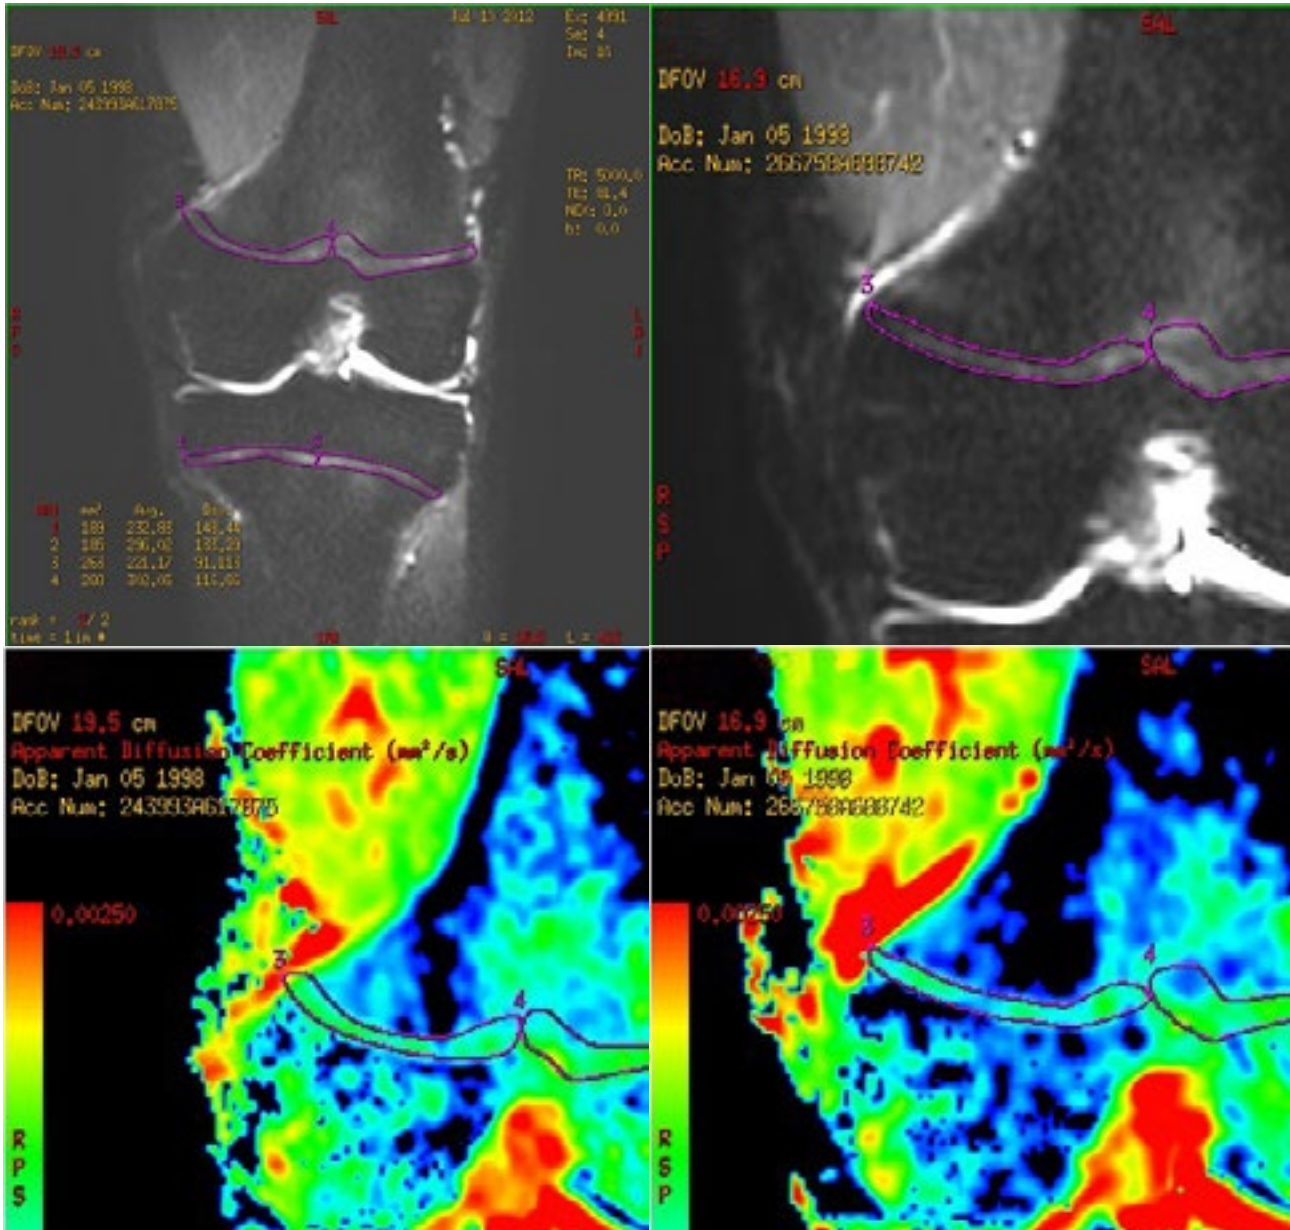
A sample of DWI analysis of growth plate in an adolescent soccer player before (A, A1) and two months after (B, B1) sport activity. There were no significant differences in growth plate surface area measured in MR images (A, B). Calculated ADC values after 2 months were decreased and may reflect an increased cellularity of the growth plate (A1, B1) (reproduced with permission) (19).
